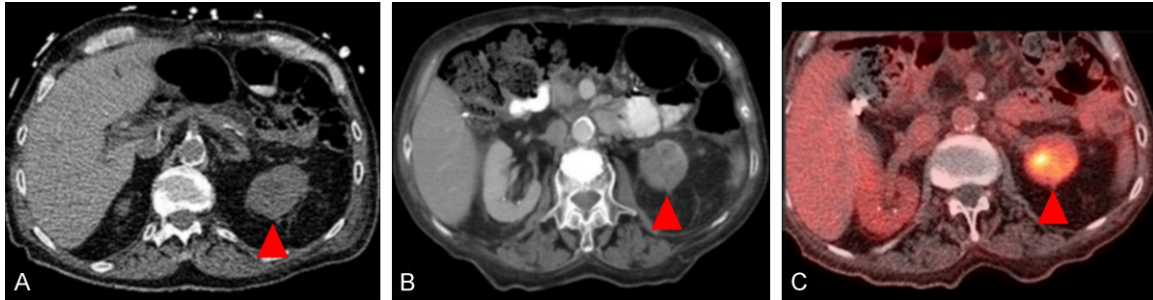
Incidentally discovered urothelial lesion on SPECT/CT (case 1 above). A. Attenuation correction CT of the abdomen shows poorly visualized but visibly abnormal mass lesion in the posterior aspect of the left kidney (red arrowhead). B. On later contrast-enhanced CT, lesion (red arrowhead) enhances but is still less bright than contralateral kidney. C. On a later FDG PET/CT, the lesion (red arrowhead) is slightly more avid than adjacent kidney.
